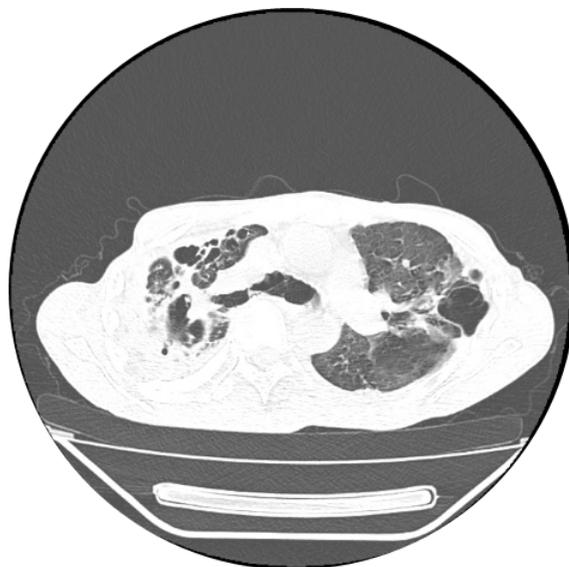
Non-contrast chest computed tomography, lung window, apical slice.
